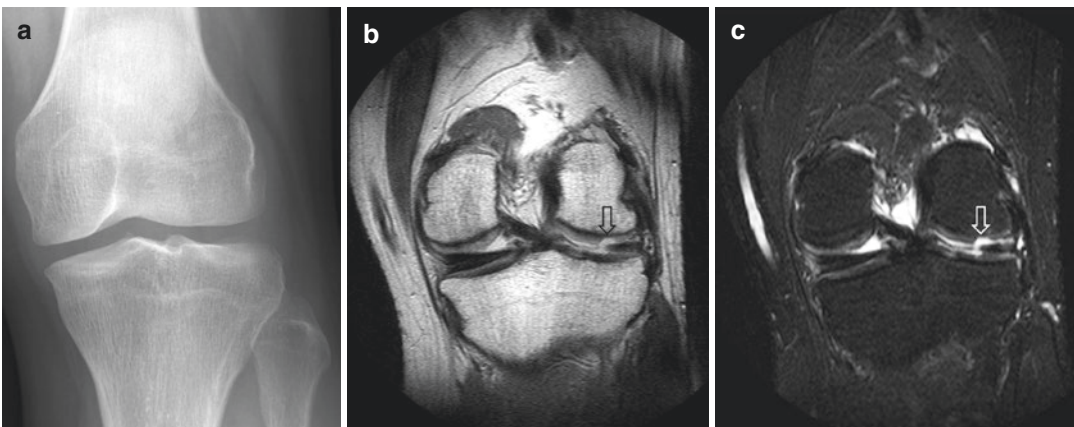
A 42-year-old man who presented with left knee pain. (a) Frontal radiograph of the left knee shows minimal degenerative changes with preservation of the joint spaces. Coronal (b) PD-W and (c) fat-suppressed
